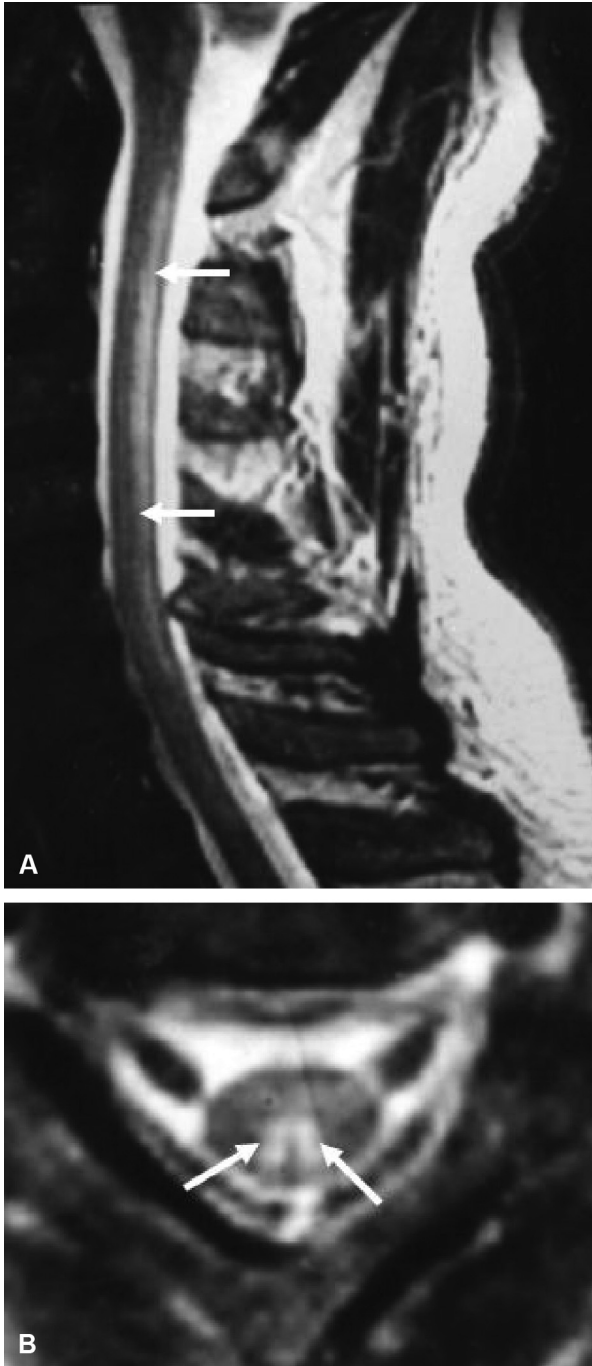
Magnetic resonance imaging (MRI) in cobalamin deficiency. T2-weighted sagittal (A) and axial (B) MRI of the cervical spinal cord from a patient with myelopathy due to cobalamin deficiency showing increased signal involving the dorsal column. (Adapted from Hemmer et al., 1998, with permission.)
